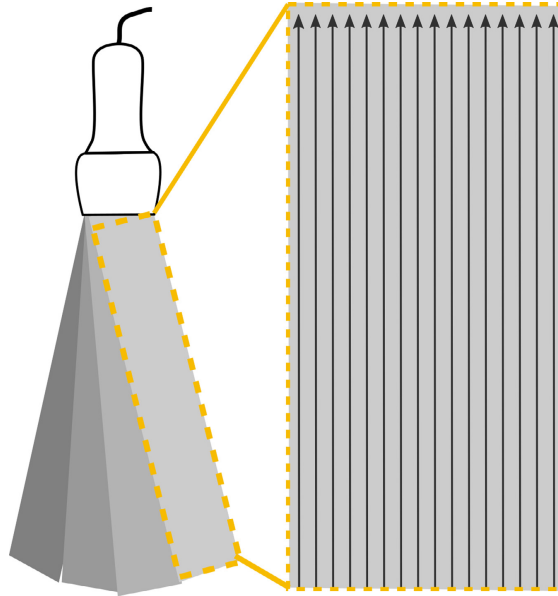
Plane wave imaging and parallel receive beam forming. In this study, we used three to nine plane wave directions to cover the Doppler sector width. For each plane wave transmitted, multiple image lines (16 in our setup) were received simultaneously. Tracking can be done within the region covered by the 16 receive lines, where the frame rate equals the pulse repetition frequency.
